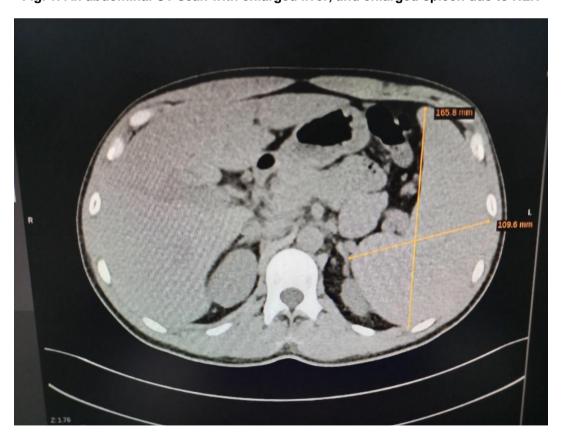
an abdominal CT scan with an enlarged spleen
